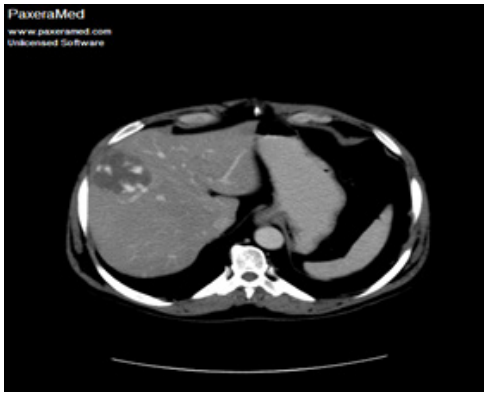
A 40-year-old male patient. Axial CT image arterial phase shows peripheral enhancement of hemangioma.
